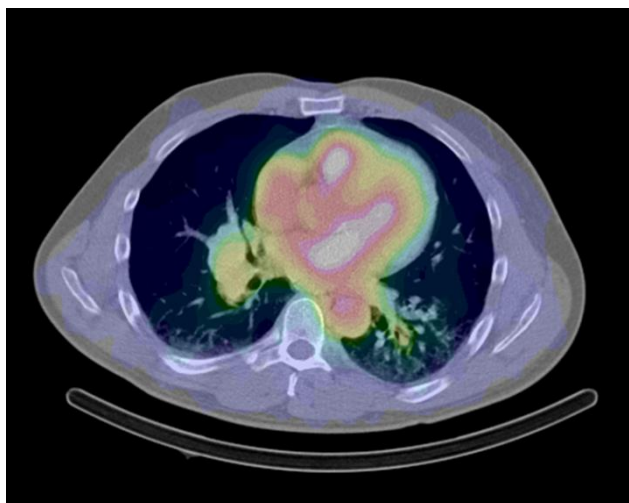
Overlay of high heart activity uptake in patient 1 on CT image
